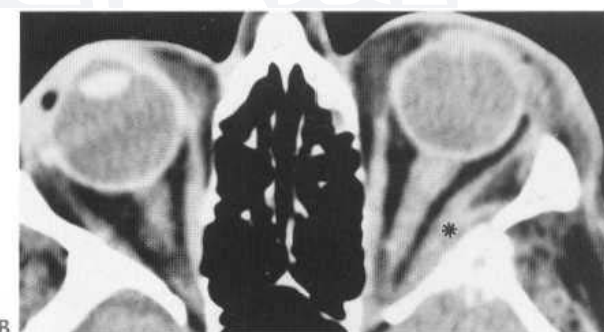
Metastatic prostate carcinoma. Axial CT image (A) through orbits demonstrates small lytic lesion of left lateral orbital wall in a patient with prostate carcinoma. Soft-tissue windows (B) demonstrate contiguous extension of soft tissue into lateral extraconal compartment (asterisk) with medial displacement of the lateral rectus muscle.
